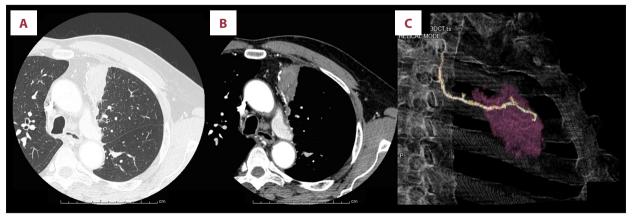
Findings from preoperative computed tomography of the chest in Case 1. (A, B) Lung window setting (A) and mediastinal window setting (B) show a smooth marginated mass along the staple line of the left lingular segment. (C) Three-dimensional computed tomography helps to understand the morphology of the mass (purple shadow).
